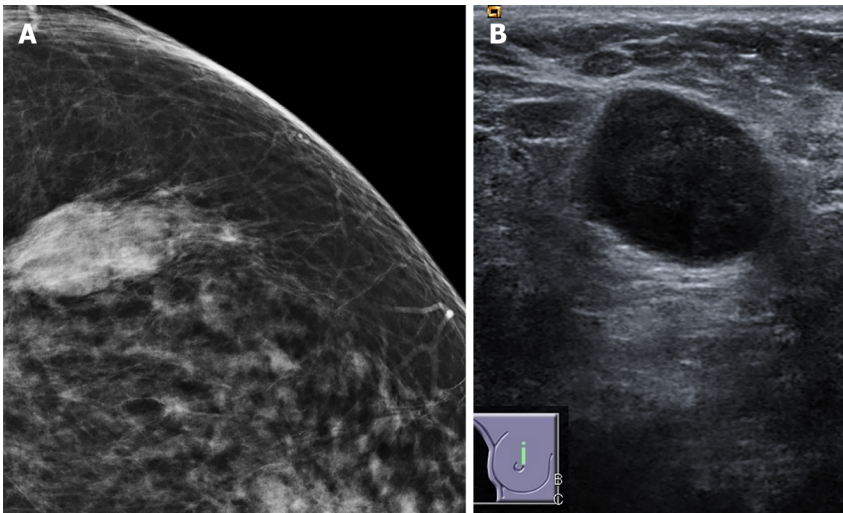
Triple negative breast cancer. A: Circumscribed mass on mammogram; B: Circumscribed hypoechoic mass with posterior acoustic enhancement on ultrasound.
